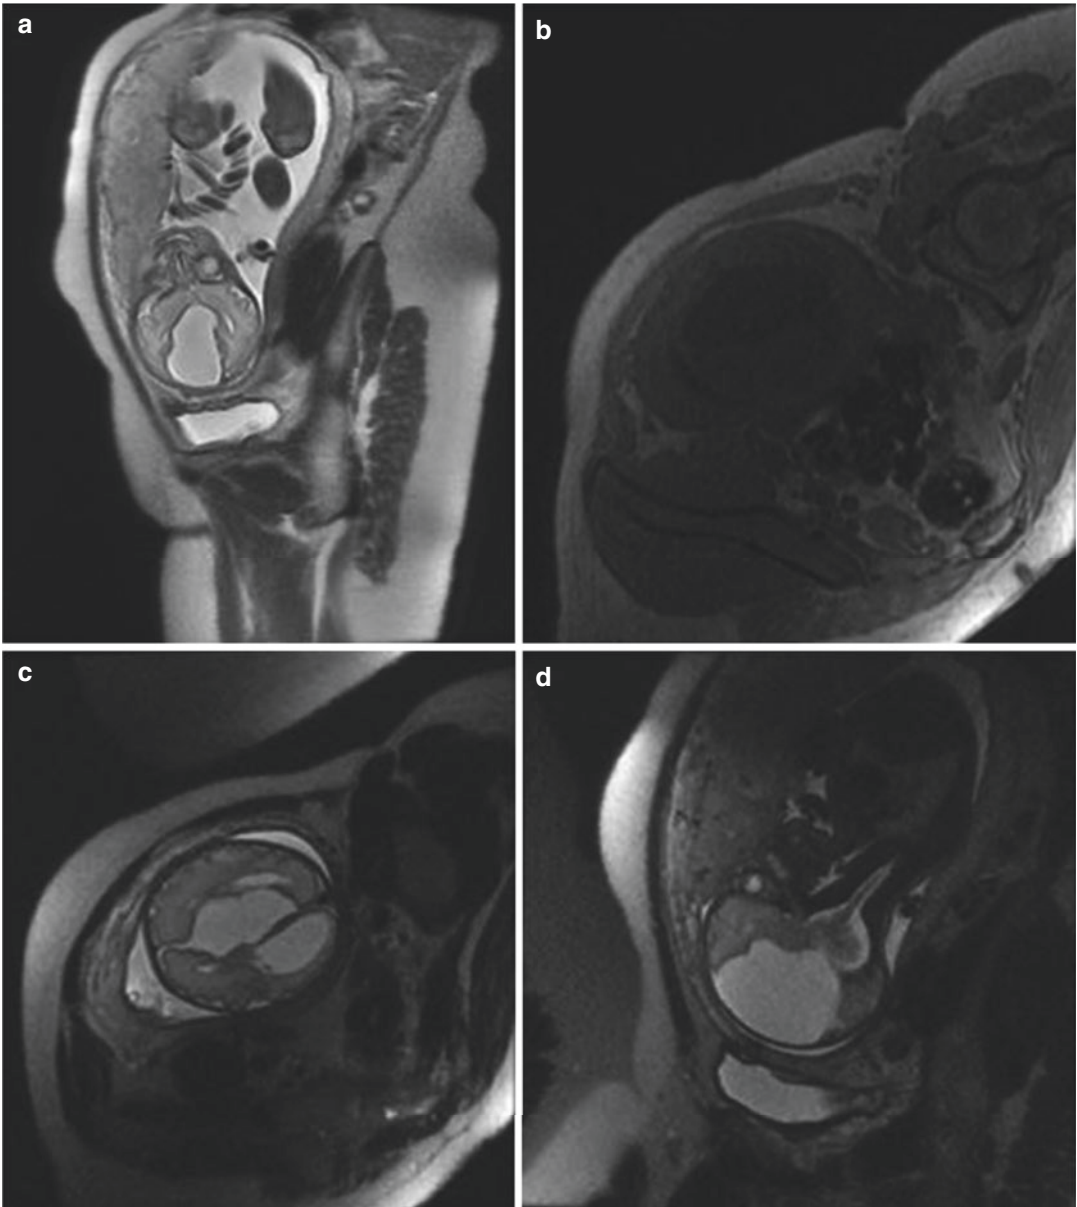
(a–d) Quadrigeminal plate AC. (c) Cine images show a signal void due to flow. Since no contrast agent is administered intrathecally, MRI cine cisternography is one of the noninvasive tools for diagnosing flow in the cyst
